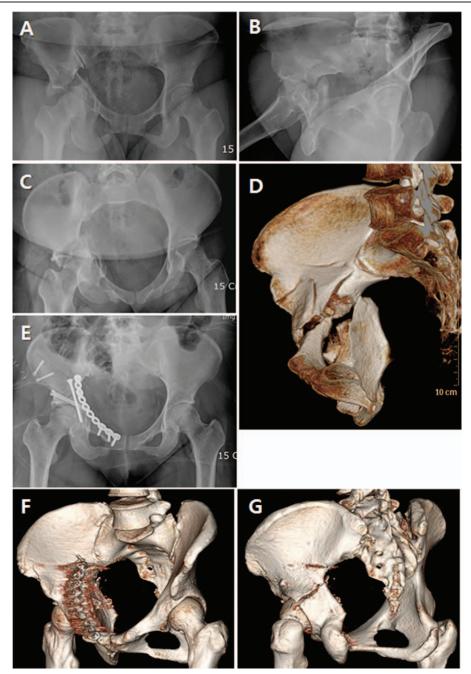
A 48-year-old woman suffered from acetabular fracture associated with both column fractures, which identified at the anteroposterior (A), oblique (B), pelvic inlet (C) radiograph. 3D-CT reconstruction image shows the acetabular fracture clearly (D). Postoperative anteroposterior radiograph (E) and 3D-CT reconstruction images (F, G) after the internal fixation of the acetabular fracture shows a good reduction of the acetabular fossa and both column and the ilium. 3D-CT = three dimensional computed tomography.
